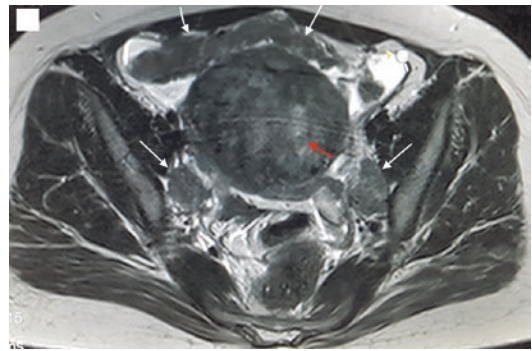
T2-weighted MRI of a patient with DPL and a large uterine fibroid; white arrows point to the peritoneal leiomyomata; red arrow, uterine fibroid
